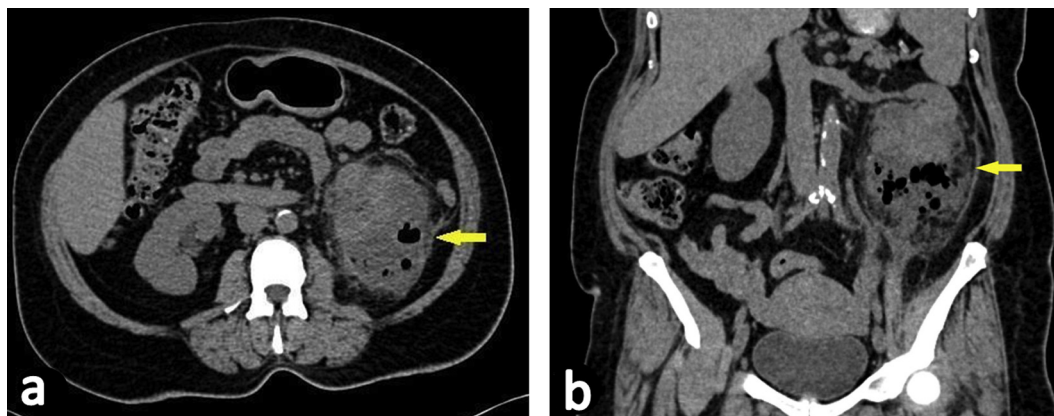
Fifty-three year old diabetic female patient with left flank pain. CT stone protocol in axial (a) and coronal (b) planes through the kidneys shows left renal abscess (arrows). No stones were found.
